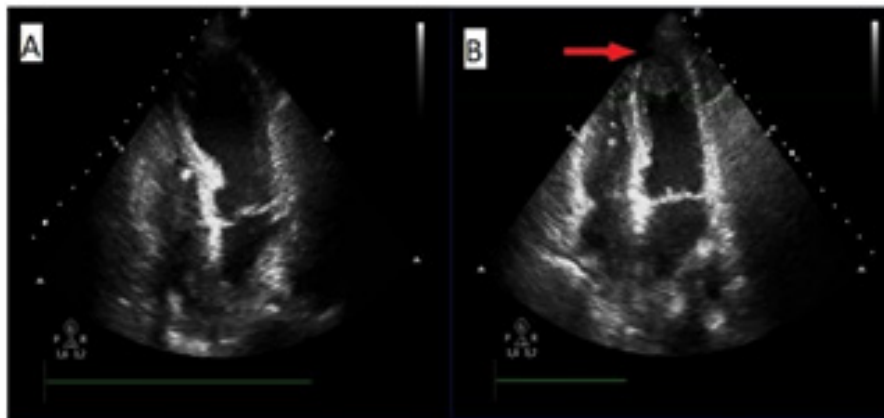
2A. Transthoracic echocardiography. 4-chamber view shows severe left ventricular dysfunction with apical hypokinesis. 2B. Transthoracic echocardiography. 4-chamber view reveals recovery of left ventricular function and apical thrombus.
